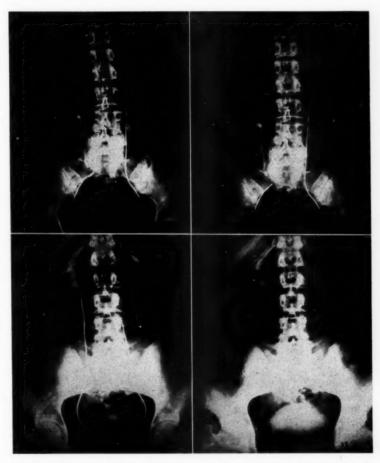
(upper left). Case 5. Roentgenogram made after the injection of diadrast demonstrating a block at the ureteropelvic junction.
